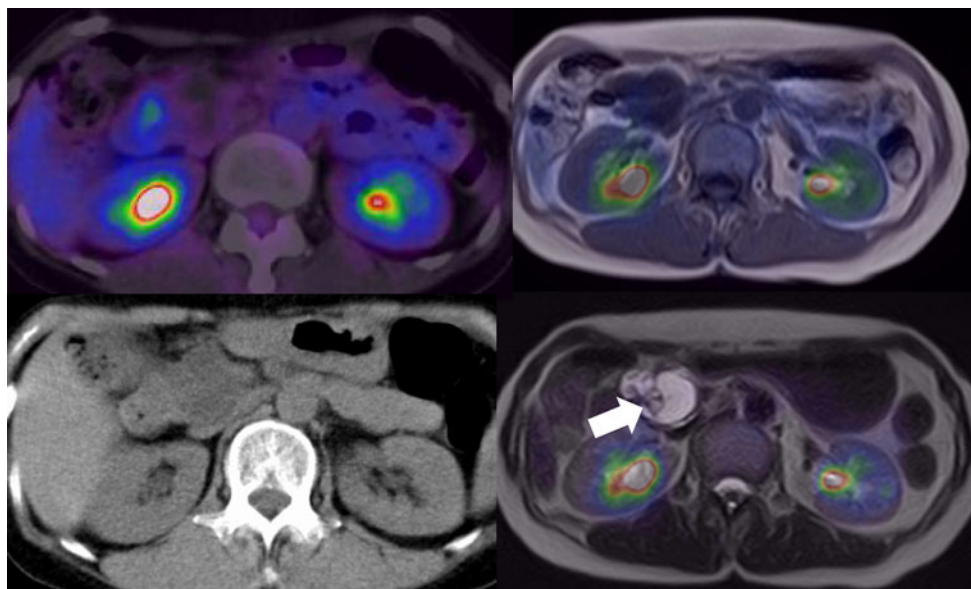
Low-dose CT (*left lower*) and PET/CT (*left upper*) demonstrated FDG-negative cystic lesion adjacent to duodenum. The case was diagnosed as IPMN by PET/CT. PET/MRI-T1 fusion image showed intra cystic septum without FDG uptake (*right upper*). PET/
